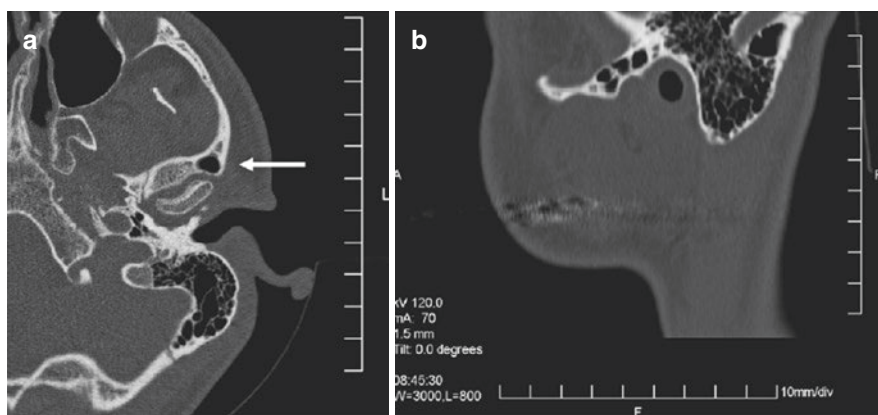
CT scan revealing air cells in the eminence (a) coronal (b) axial (Courtesy Prof. N. Shaun Matthews)
